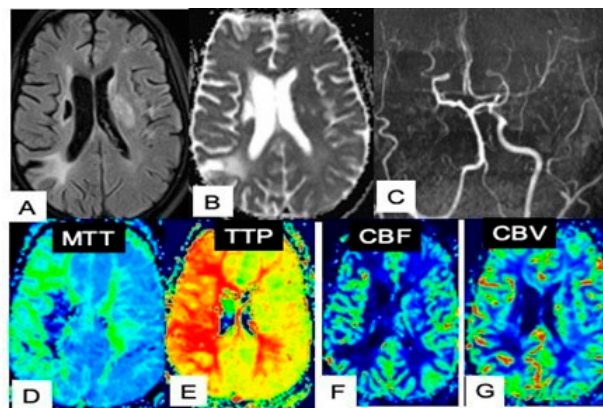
MRI of the brain. (A) Axial FLAIR and (B) axial T2W image showing multiple infarcts and ischemic zones in both hemispheres. (C) MRA of the brain showing an occlusion of the right ICA and scarcity of the right MCA vessels. (D–G) Perfusion MRI showing ischemic “penumbra”. Source: Figure by authors.
